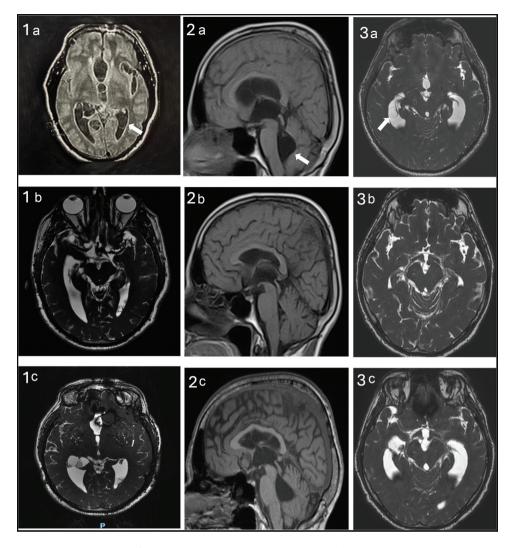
Magnetic resonance imaging (MRI) scans of patients (#1 to #4) with ventricular NC at initial presentation (a) Arrows point the cysts), after treatment (b) and at relapse (c).
